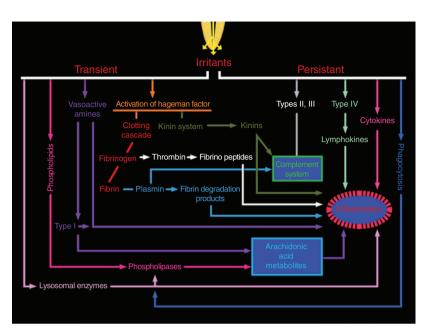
Egress of irritants from an infected root canal into periapical tissues can result in activation of nonspecific as well as specific immunologic mediators of inflammatory reactions.
